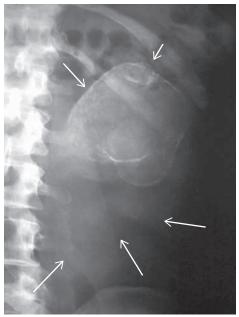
Renal calcification. Plain radiograph shows calcification in the upper half of the left kidney. *Arrows* outline the kidney.
